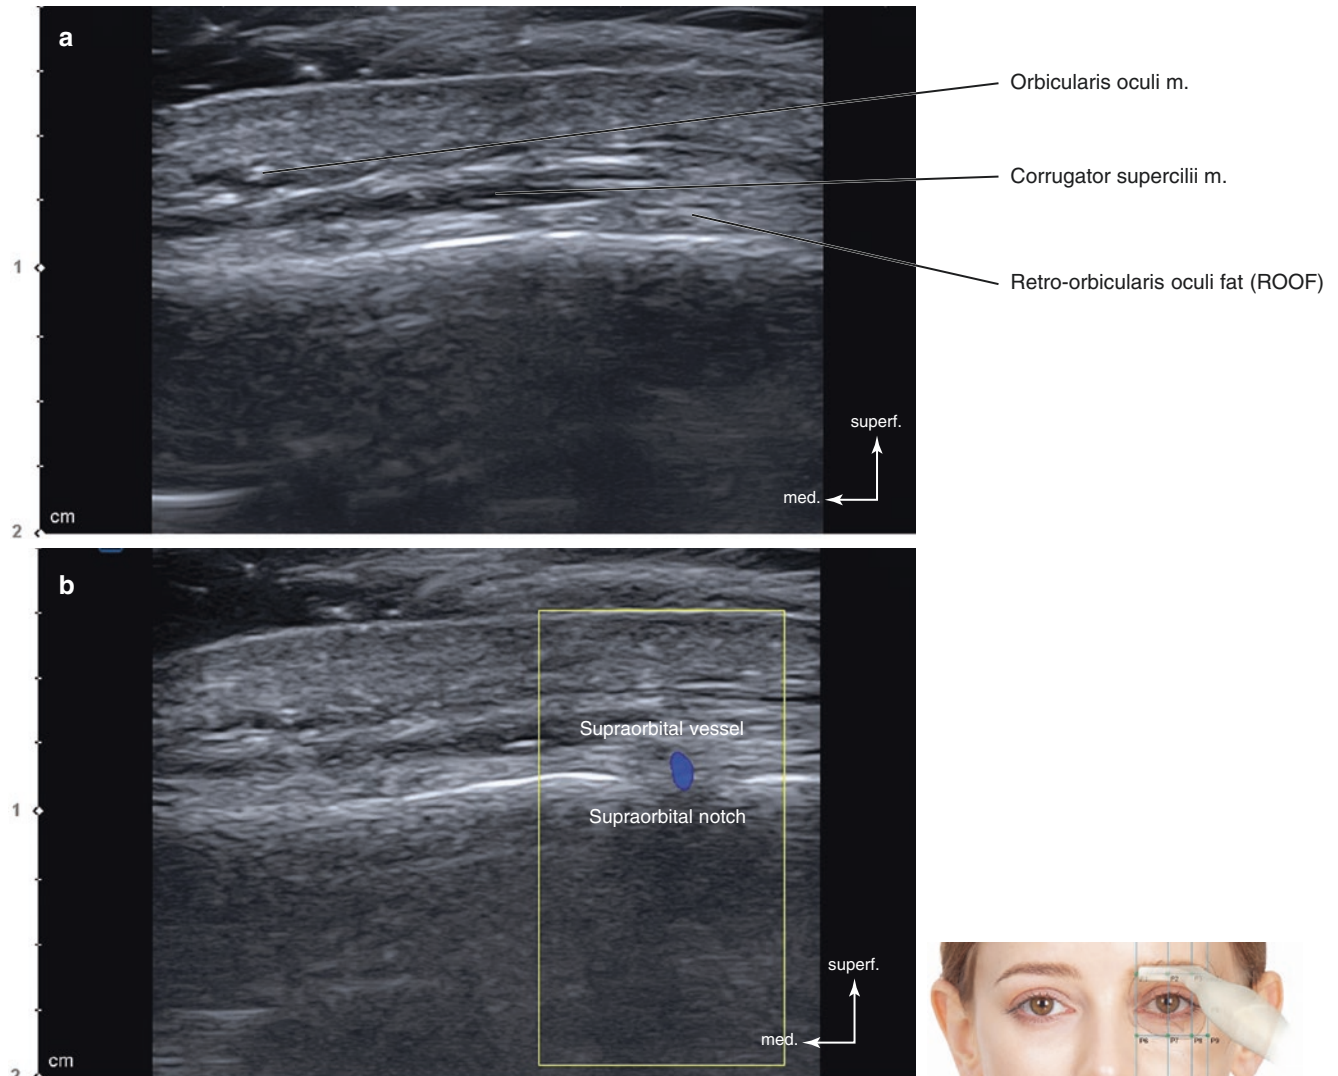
Ultrasonography on the intersection point of TL2 and PL2 (P2). (a) B mode (transverse view, 15 MHz by linear transducer), (b) Doppler mode (transverse view, 15 MHz by linear transducer), (c) B
